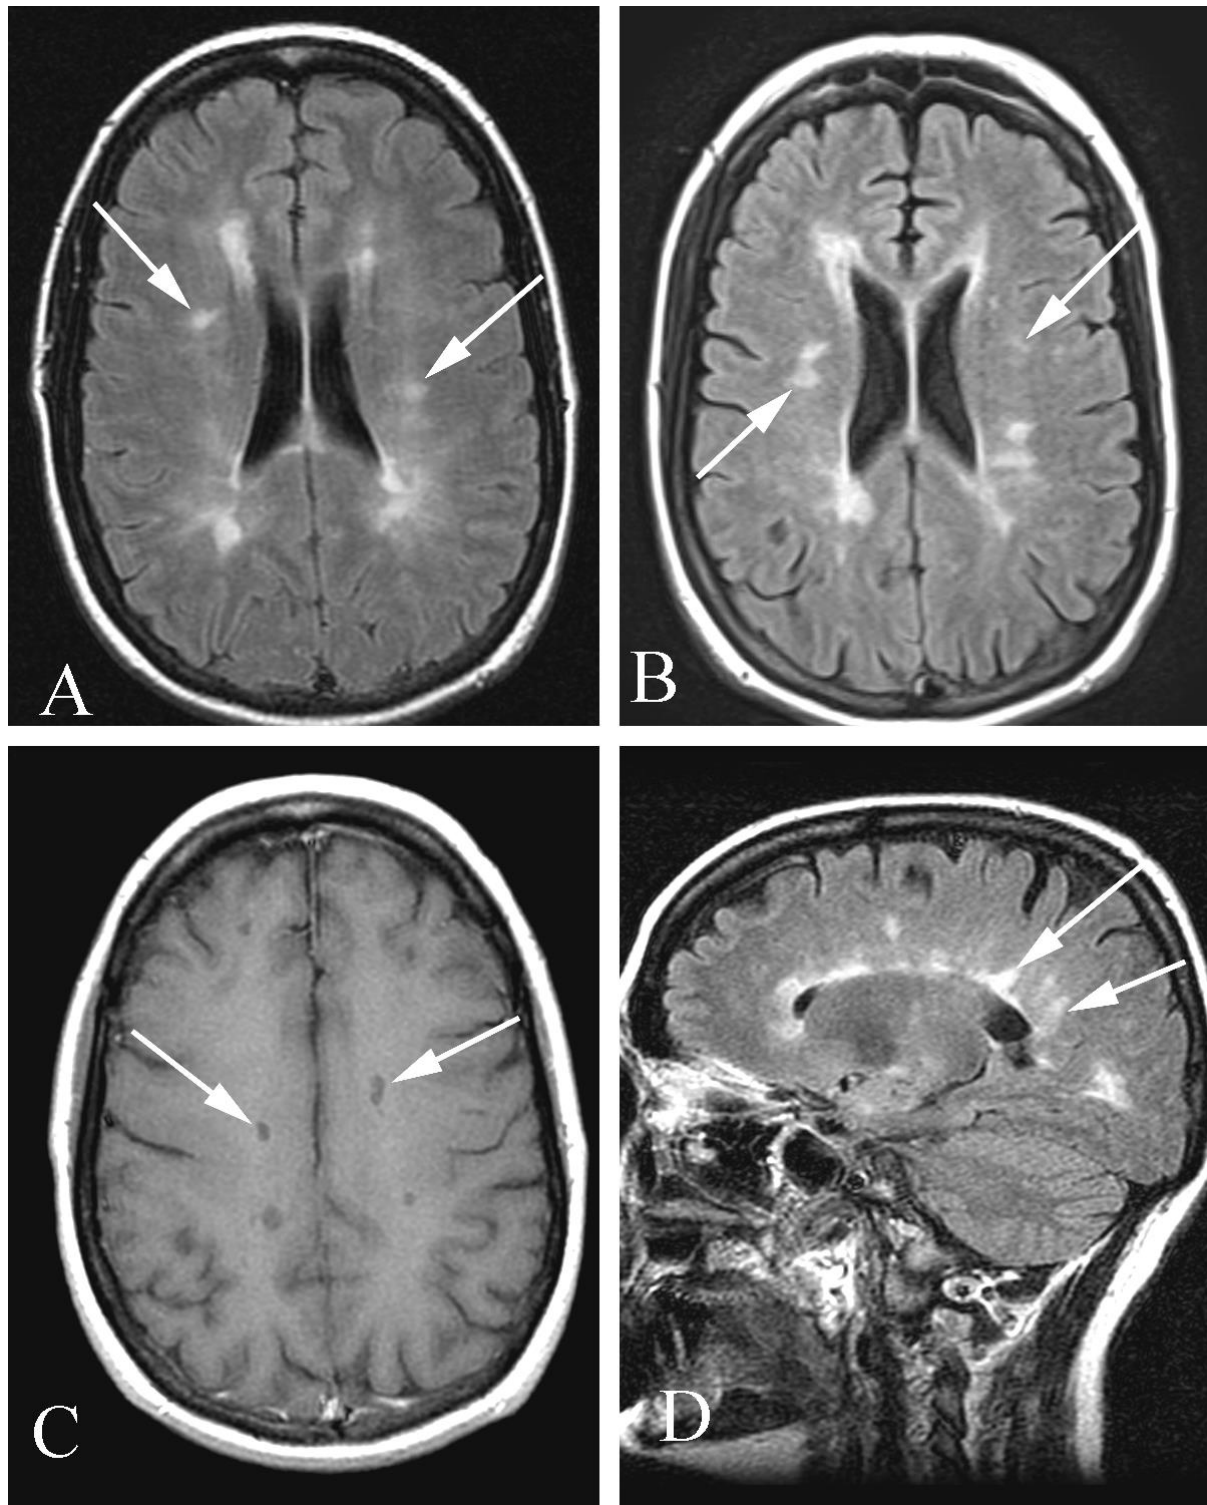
Multiple sclerosis in a 41 year old woman with diplopia. A. Axial FLAIR MR shows multiple foci of increased signal intensity (arrows). B. Axial FLAIR MR at a slightly different level shows multiple additional oblong foci of increased signal intensity (arrows) with the long axis of the abnormalities perpendicular to the lateral ventricles. C. Axial T1 weighted post-contrast examination shows multiple foci of decreased signal intensity (arrows) in the white matter of the cerebral hemispheres. D. Sagittal FLAIR MR shows multiple foci of increased signal intensity, including several lesions of the corpus callosum (arrows), typical for multiple sclerosis.
